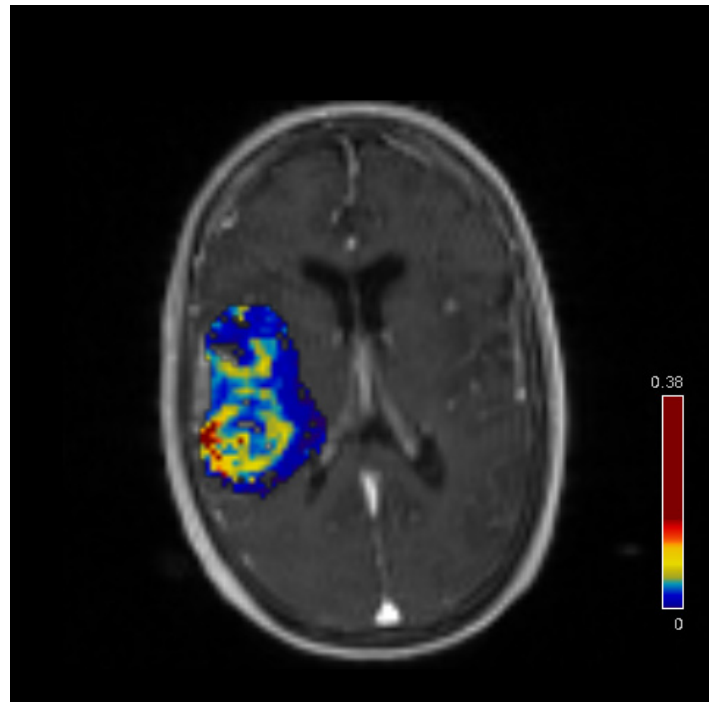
MRI with DCE of a stroke patient. Colour scale represents the K_{trans} values obtained from a specific Region of Interest, manually defined to include an ischemic lesion within the territory of the right middle cerebral artery.
